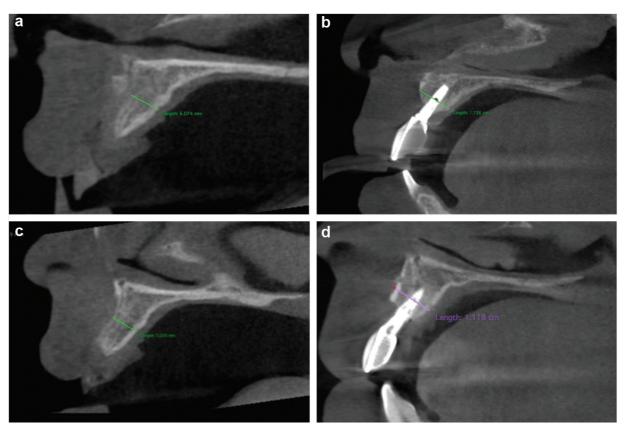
Cone beam computed tomography evaluation of (a, b) tooth 21 shows 5-mm gain at 6 months postoperatively and (c, d) tooth 22 shows 4-mm gain on the bone at 6 months postoperatively.
